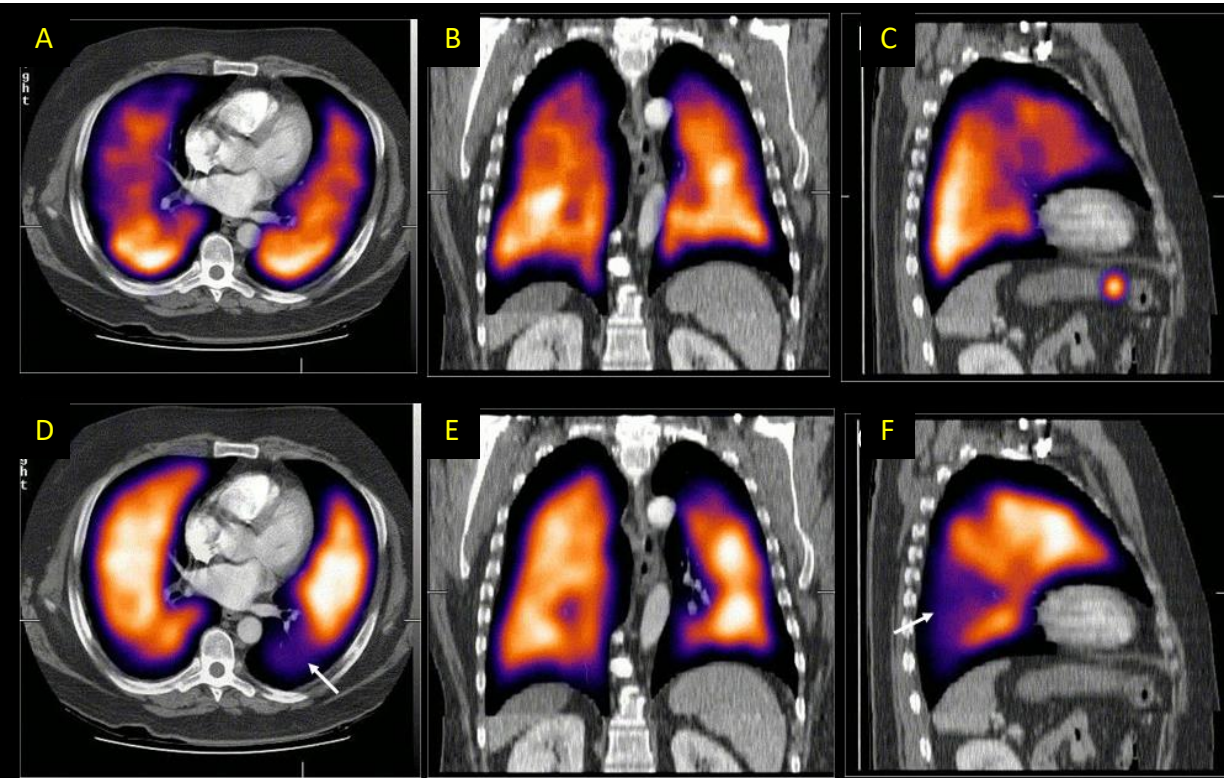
Representative slices of a SPECT/CT fused imaging of lung ventilation (top row) and perfusion (bottom row). The fusion SPECT/CT images demonstrates a segmental perfusion defect (arrow in 7D and 7F) in the left lower lobe with no CT opacity or matched ventilation defect consistent with pulmonary embolism. Image from (3) and used with permission.
